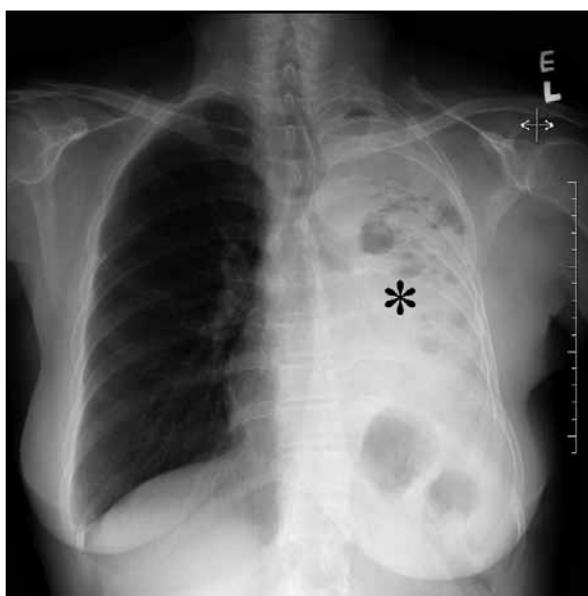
Chest radiograph showing an opacified left hemithorax with abnormal air lucency in the upper zone (*)
